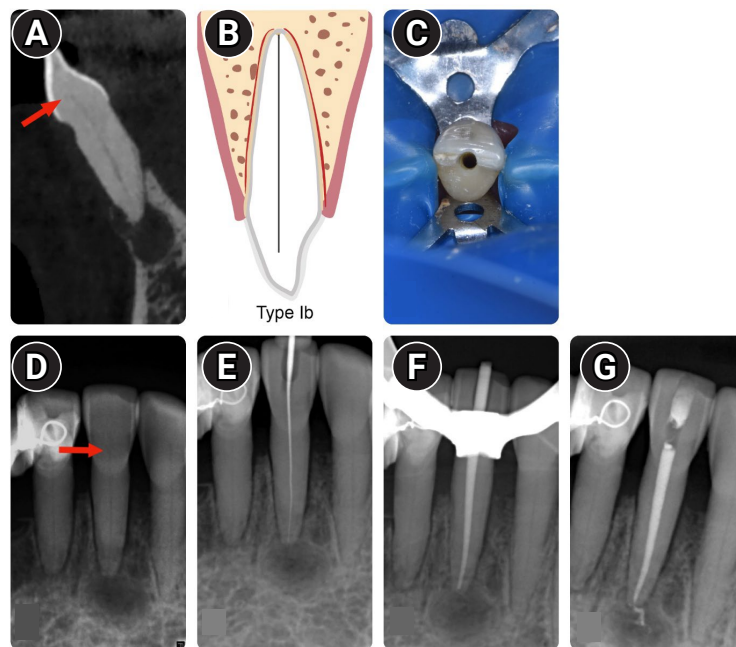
Characteristics of Type Ib root canal classification. (A) Tomographic image. The red arrow indicates the target point (start of the canal), which is located in its original position; however, narrowing of the canal lumen is observed along the entire root. (B) Type Ib classification scheme. (C) Access to pulp chamber/root canal. (D) Initial radiograph. The red arrow indicates narrowing of the root canal along the entire root. (E) Initial root canal negotiation with a file to determine the temporary working length. (F) Gutta-percha master point fitting before root canal filling. (G) Filled canal.
